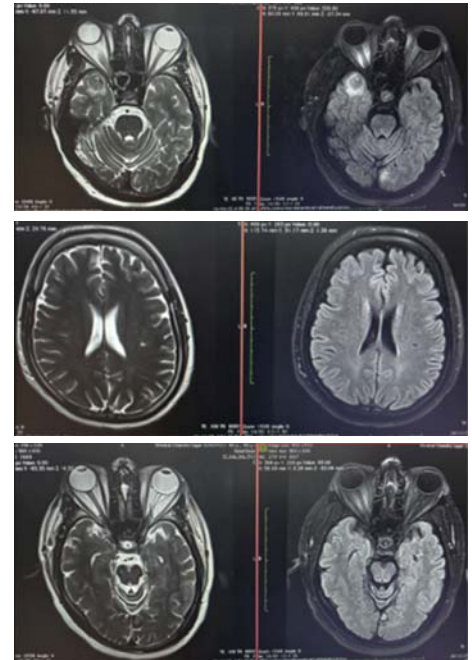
Post-treatment MRI brain with contrast
